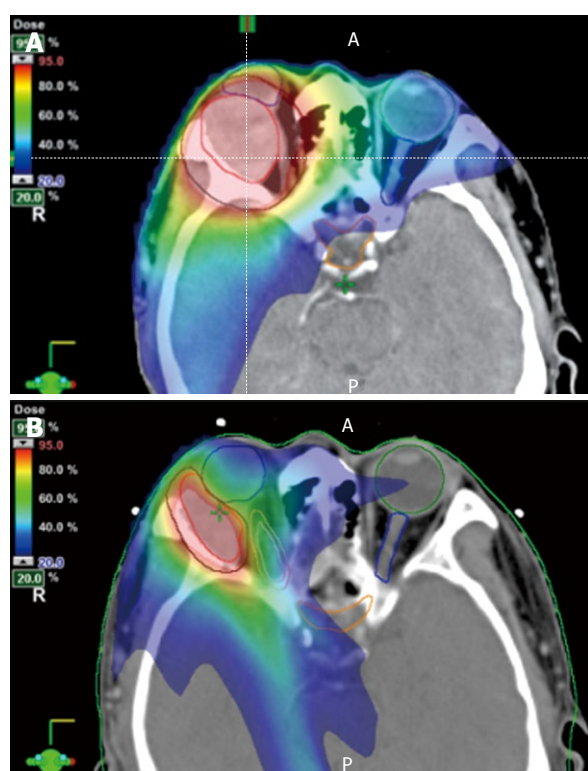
Three-dimensional contours for treatment planning demonstrate the gross target volume (GTV) encompassing the tumor (red contour) and the planning target volume (PTV, black contour) on initial (A) and boost (B) CT images. Doses from the initial 7 field intensity modulated radiation (IMRT) plan (A) are represented as color wash according to the scale shown in the figures, representing the range of 95% through 20% of dose coverage. The 7 field IMRT plan for the coned-down field (B) shows even tighter dose coverage and greater sparing of the right optic nerve (pink contour).
